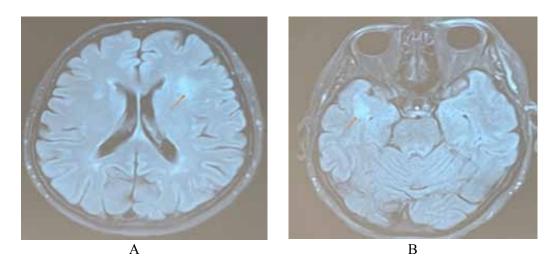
Foci of hyperintense magnetic resonance signal on T2-weighted image and FLAIR impulse sequence in the right temporal lobe (B); in the white matter of the frontal lobes.
